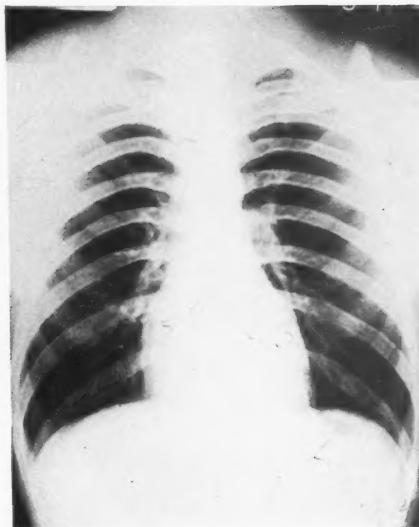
(left). X-ray film of chest showing a large pericardial effusion.
